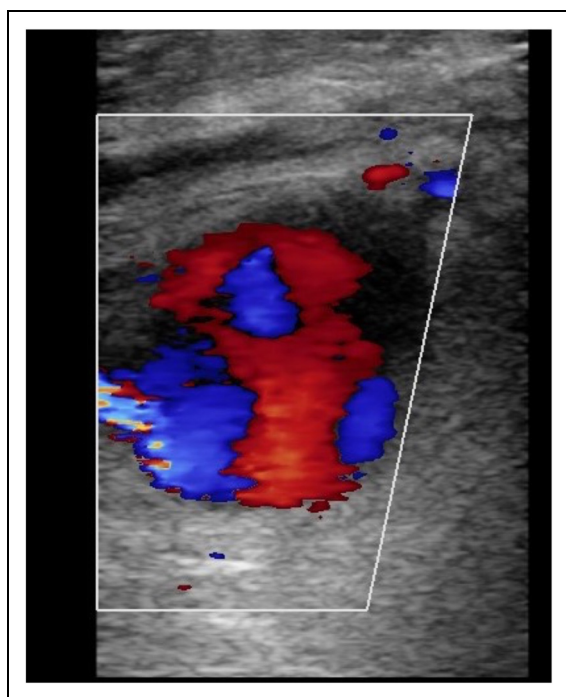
Doppler ultrasound of brachial artery showing yin yang sign compatible with pseudoaneurysm.
